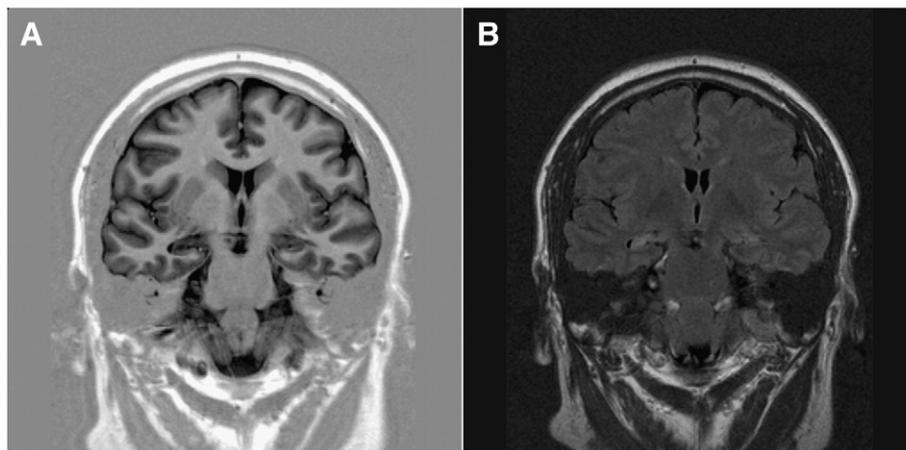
Preoperative MRI scans showing right hippocampal atrophy, loss of the hippocampal internal structure, and increased signal intensity on (A) coronal inversion-recovery and (B) FLAIR weighted images.
